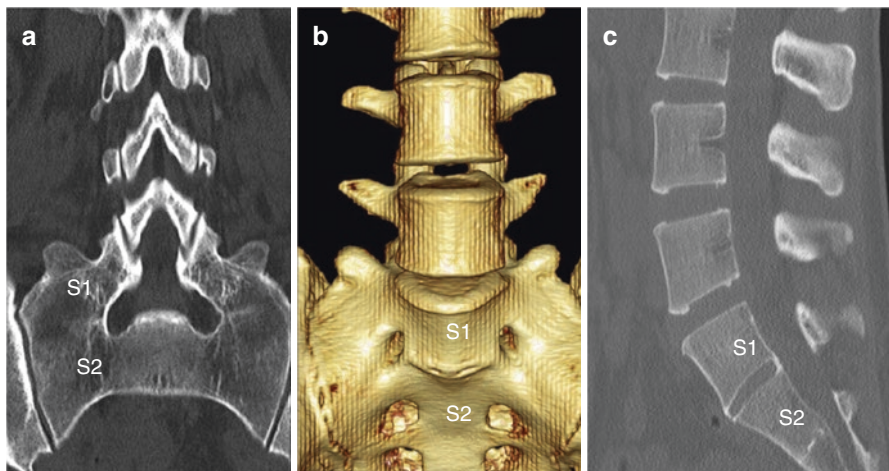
Transverse process of lumbarised S1 (transitional vertebra) fused bilaterally with the sacral transverse process below - Castellvi type IIIb seen on (a) CT Coronal reformat, (b) Volume rendered image and (c) CT Sagittal reformat. (Castellvi types I, II and III depends on transverse processes being large-dysplastic, showing pseudo-articulation with sacrum and complete osseous fusion with sacrum, respectively. Subtypes are further classified unilateral (I/II/III a) or bilateral (I/II/III b). Whereas type IV (with no subtype) is combination of unilateral type II and contralateral type III)
